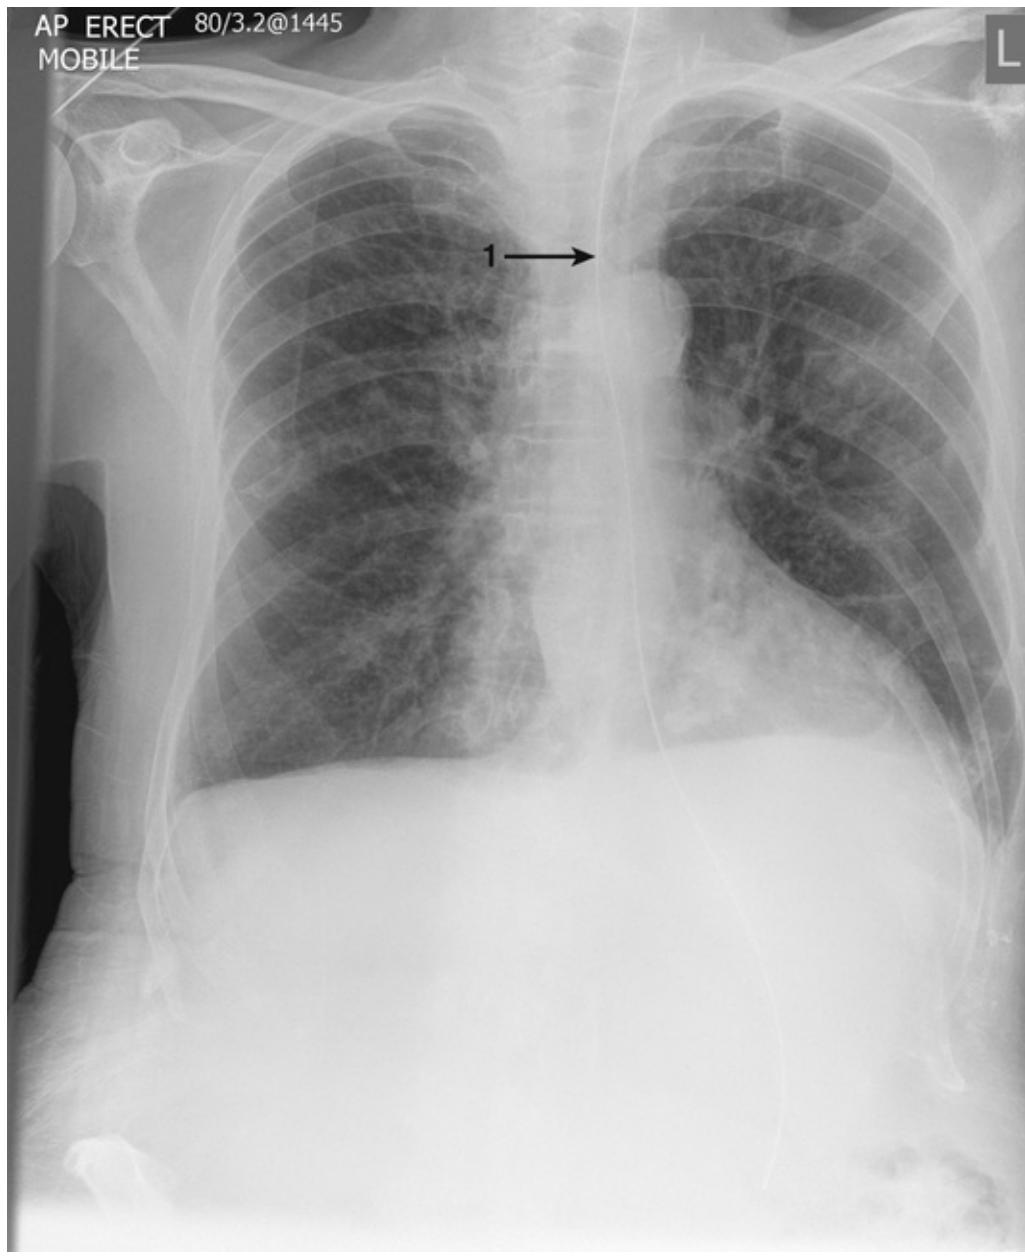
A CXR of a 70-year-old man who had a protracted hospital stay following an episode of sepsis. A nasogastric tube has been inserted (1). You can follow the tube from the top of the x-ray to its tip, which is below the diaphragm. The tube is smooth and not kinked and should function well.
